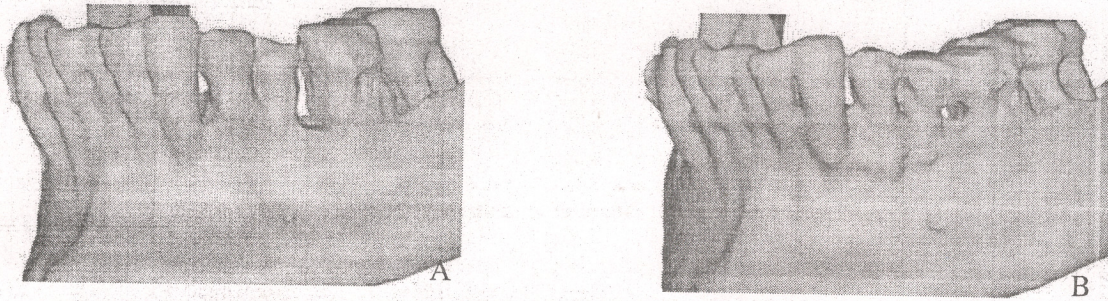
Cone beam computed tomography reconstruction. (A) Three-dimensional reconstruction of mandible to visualize the spatial topography of intrabony defects in position teeth 3.3-3.7. (B) Three-dimensional reconstruction of mandible one year after surgery. Radiographic signs of the interdental septa bone tissue restoration in position teeth 3.3-3.6
